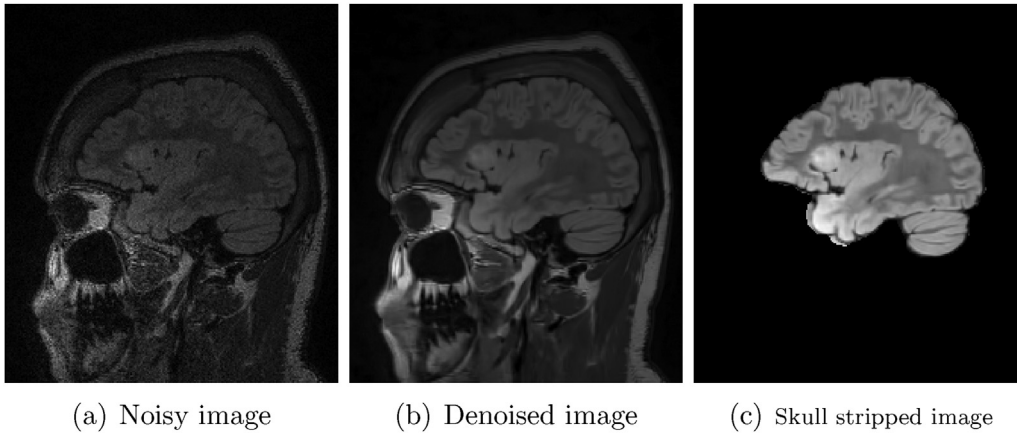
Preprocessing steps on a sample MRI frame.
